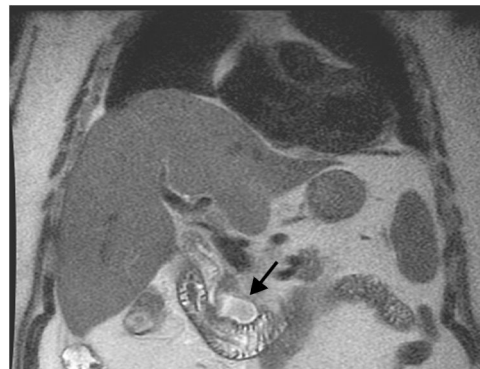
Abdominal T2-MRI scan. T2-contrast magnetic resonance imaging (MRI): a large juxtapapillary diverticulum (arrow) without intrahepatic or extrahepatic biliary dilatation.
